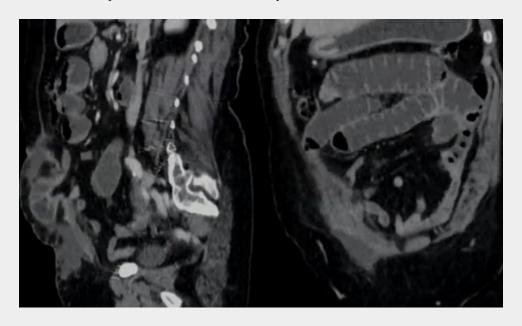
Abdominal CT in a patient with abdominal pain 36 hours after surgery
